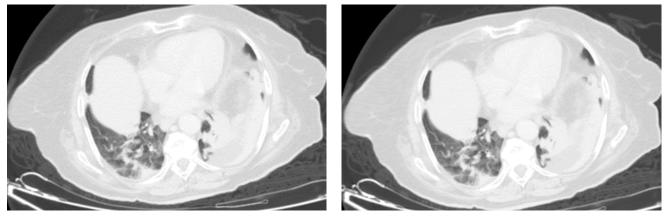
Thoracic CT showed concoliated area containing air bronchograms at the level of the left lung lower lobe posterobazal segment, band consolidated/atelectasis area at the level of the right lung lower lobe posterobazal segment and pleura effusion in both hemitoraxes.
